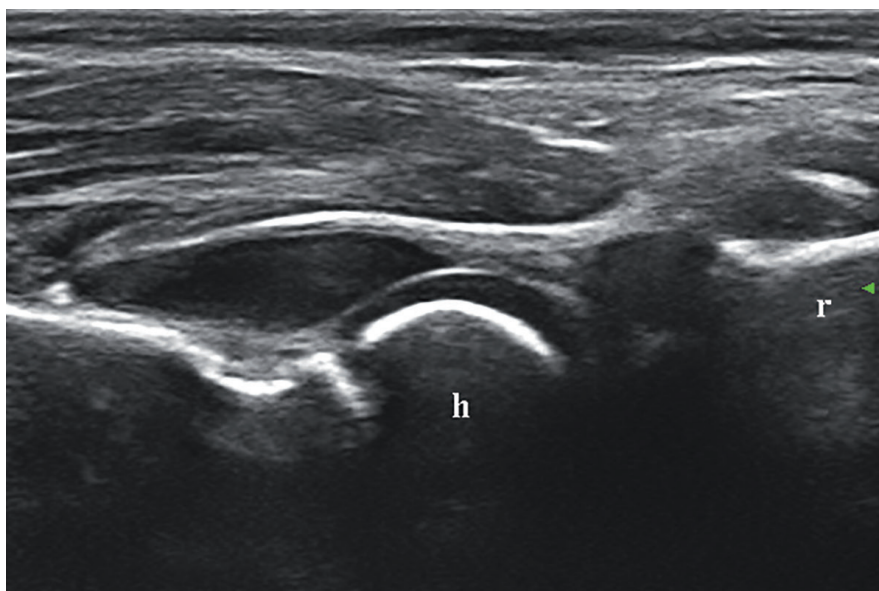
Longitudinal ultrasound image of the anterior recess of the elbow that shows synovitis in a 5-year-old patient with idiopathic juvenile arthritis. h: humerus; r: radius.
